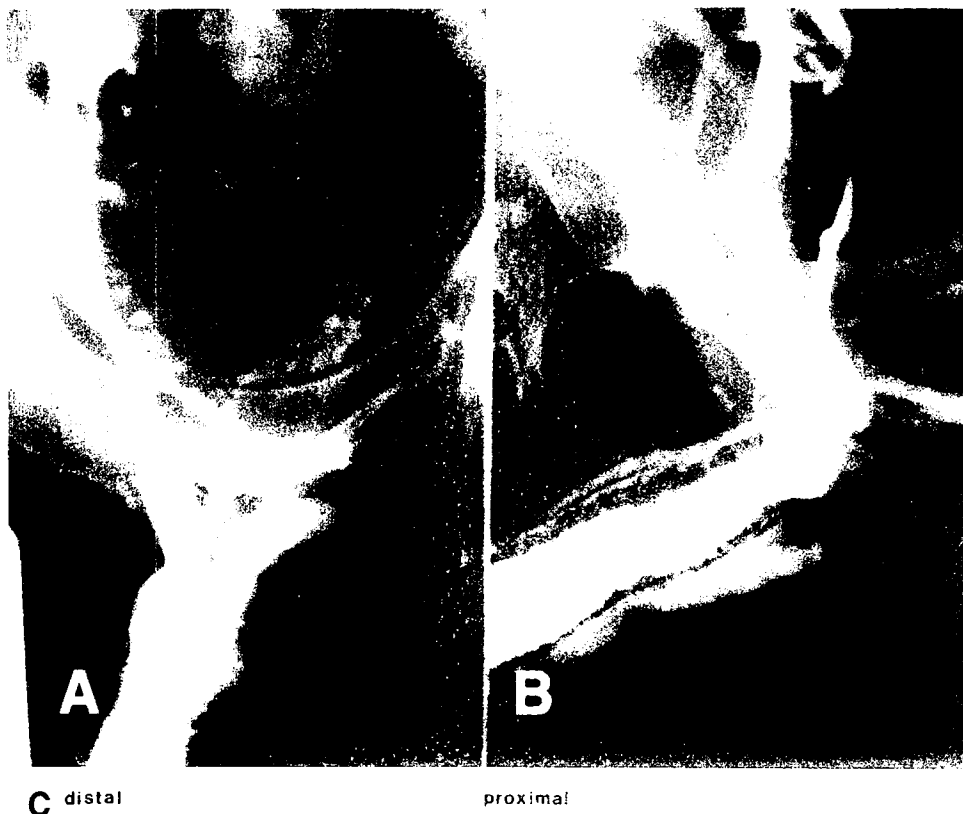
Course of deep dorsal penile vein (A and B) cavernosography, and (C) Doppler ultrasound.
